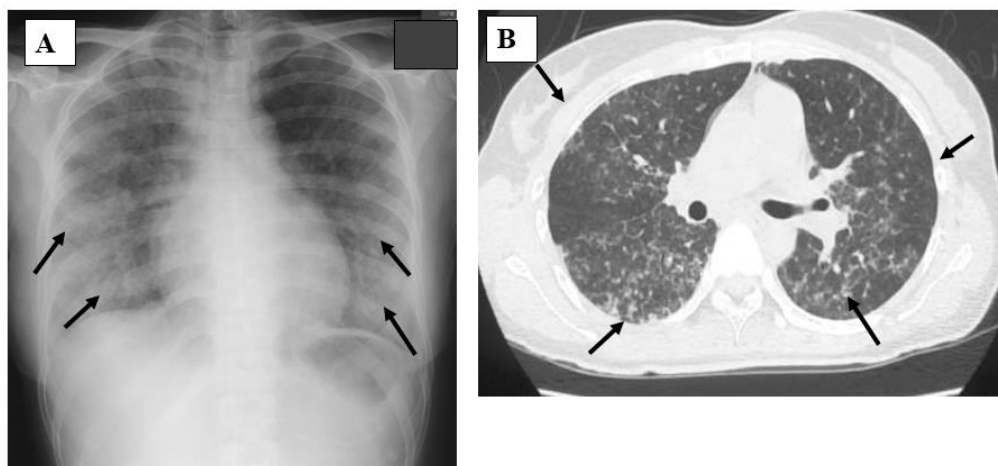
Chest X-ray (A) and computed tomography (B) findings of a 33-year-old man with measles pneumonia. Slight bilateral ground-glass shadows are seen (arrows), but he showed severe hypoxia. He was ultimately rescued after respiratory management by ventilator in the intensive care unit.
